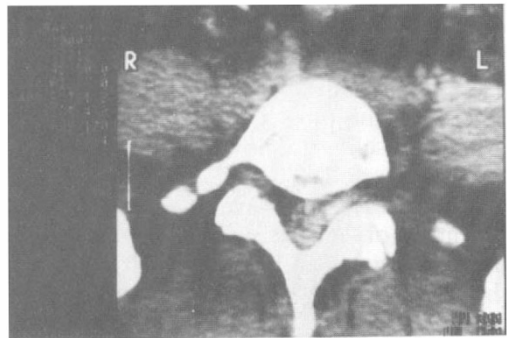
CT scan at the L5-S1 level revealed soft tissue density of equal density with the thecal sac.
